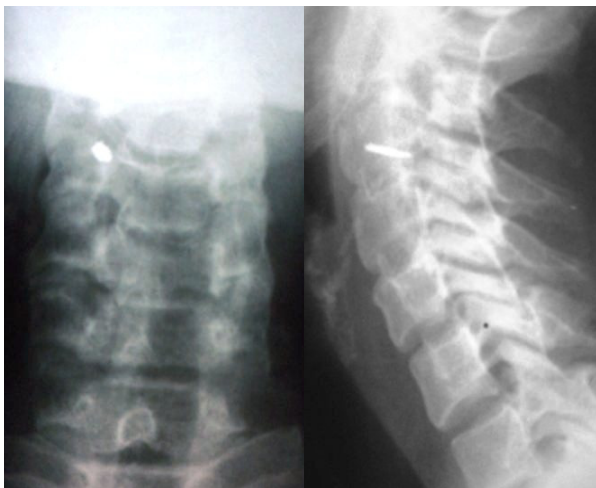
A 7x2 mm metallic object was observed at C3-4 level on the cervical plain radiograph
